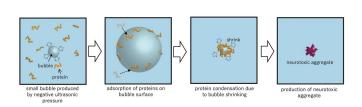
Mechanism of protein aggregation acceleration by ultrasonic cavitation. Credit: Osaka University
